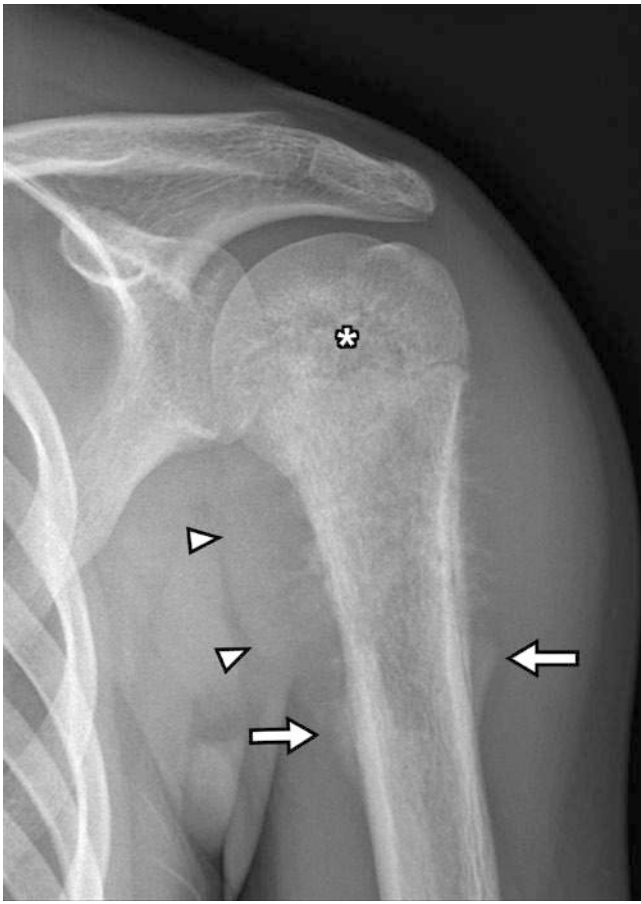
12-year-old girl with osteosarcoma. The lesion has characteristics of an aggressive process—permeative bone destruction, poorly defined margins, layered and interrupted periosteal new bone (Codman's triangle, *arrowheads*), soft tissue mass. Some spiculated osteoid production is seen within the soft mass around the bone. Ill-defined lucency and sclerosis within the humeral head suggests epiphyseal extension (*asterisk*), confirmed by subsequent MRI
